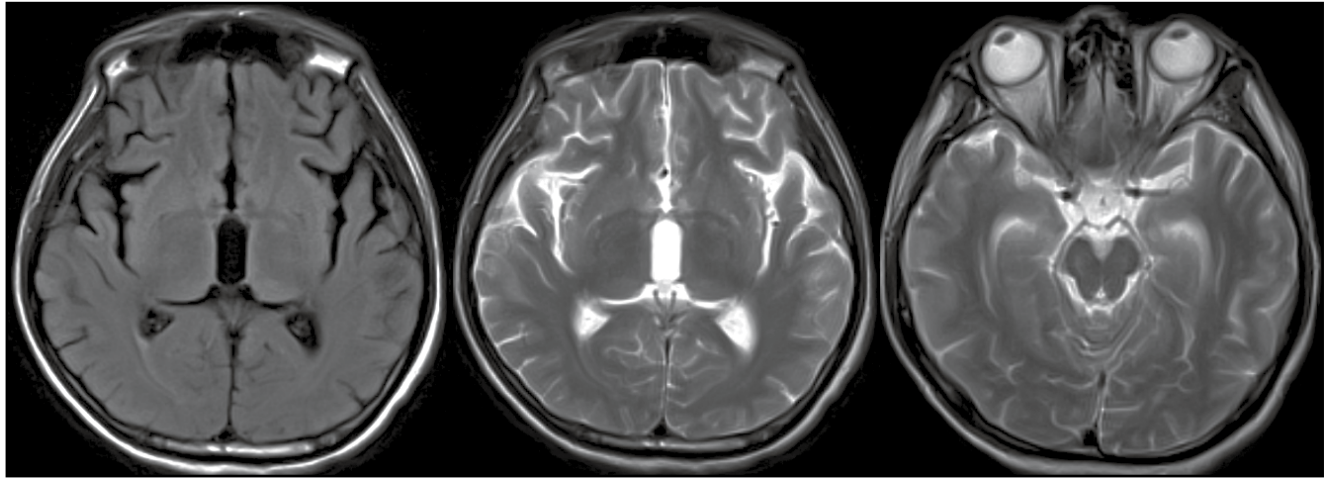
Head MRI on October 29, 2011. Sulci and sylvian cisterns were slightly widened. Original lesions disappeared completely, but suspicious abnormalities appeared in the right midbrain.
